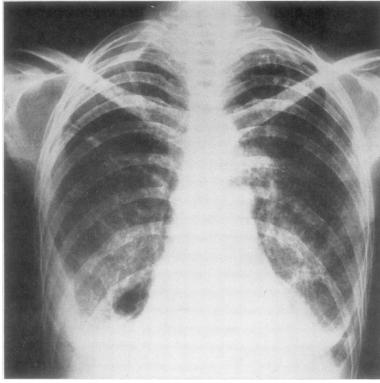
Chest radiograph taken one year before death shows encysted fluid at right base and small collection of fluid at left base. Diffuse mottling of lung fields is present, and there is a calcified lesion at the left apex.
